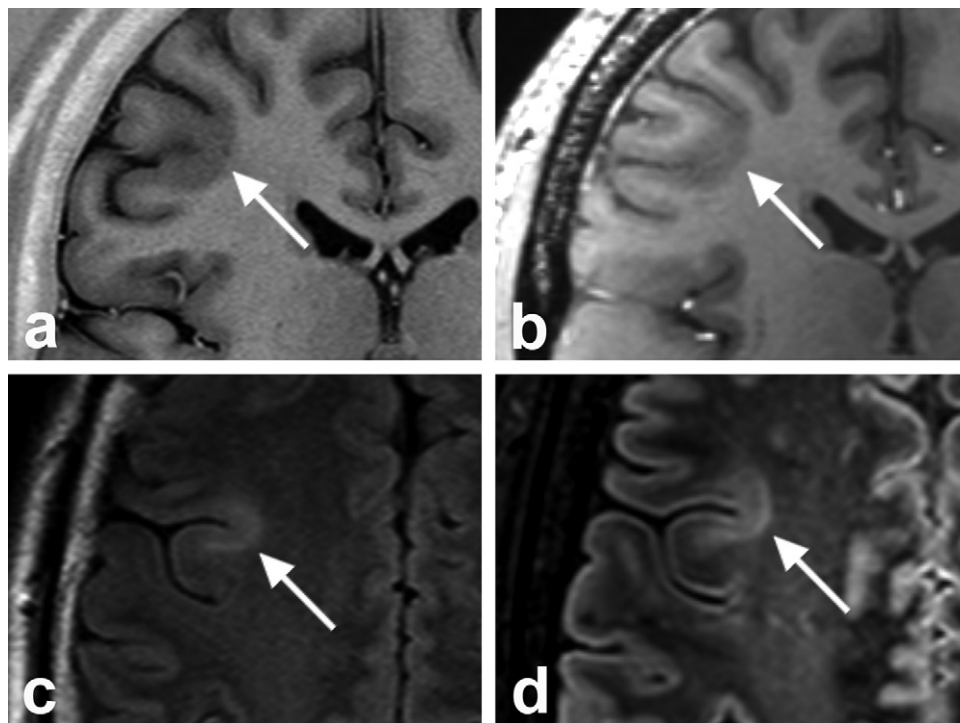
A 32-year-old male presented with symptomatic therapy-resistant epilepsy characterized by recurrent partial secondary generalized seizures and recurrent status epilepticus. a, Standard clinical 1.5T T_1 -weighted and c, FLAIR image, with corresponding images at 7T MRI (b, d). Both imaging sequences at both field strengths could visualize focal cortical dysplasia medially in the right frontal hemisphere (arrows in a–d). However, due to the higher contrast at 7T, the focal lesion was more pronounced at the 7T FLAIR image (d). Imaging parameters of the 7T FLAIR-sequence as previously published [3]; 7T T_1 -weighted sequence: shot interval 3500 ms, TI 1200 ms, TR 7.0 ms, TE 2.9 ms, 0.8 mm isotropic resolution.
